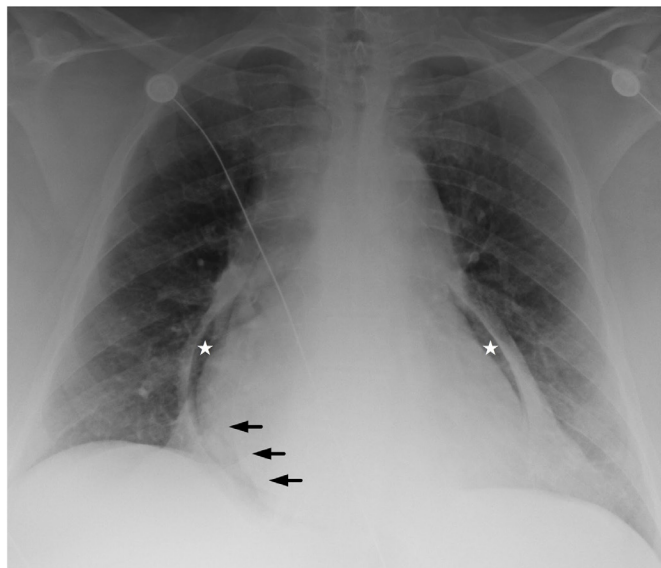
Portable anterior-posterior chest radiograph reveals pneumopericardium (stars) and dependent fluid (arrows) between myocardial and pericardial fat.
